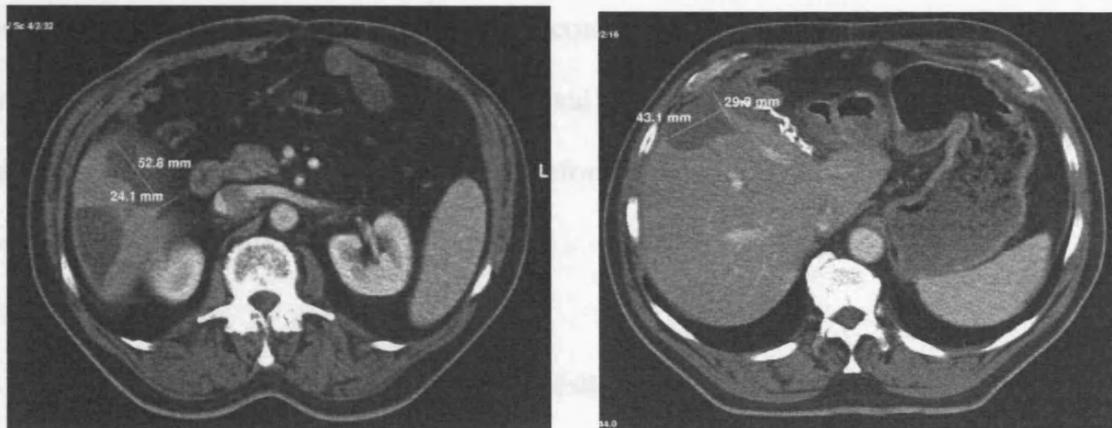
Post operative CT scan of the same patient 3 months post procedure. The sharp margins from the ablation can be seen interspersed between normal liver, the clips from the resection margin can also be seen.
